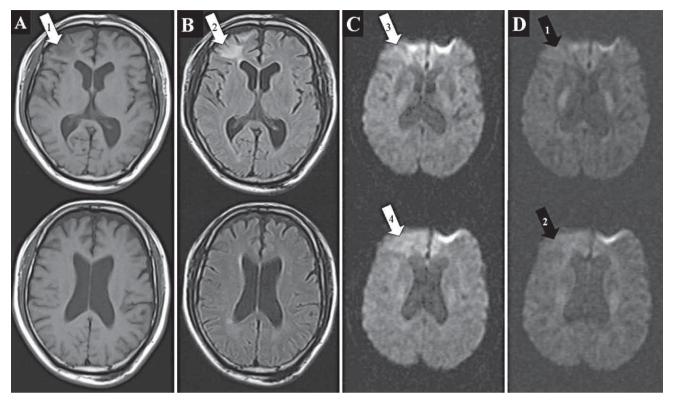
A: T1 MRI (TR/TE/excitation: 500/12/1) shows a patchy of mild hypo-intense signal in the right frontal lobe (hollow arrow 1), and dilatation of lateral ventricles. B: FLAIR MRI (TR/TE/excitation: 6,000/84/1) shows a white matter change of hyper-intense signal in the right frontal lobe (hollow arrow 2). C: Diffusion-weighted imaging (TR/TE/excitation: 8,374/148/1) shows the ischemic change of white matter (hollow arrow 3) is more of upward extension (hollow arrow 4) than T1 and FLAIR MRI. D: Although the follow-up T1, T2 and FLAIR MRI still disclose the same as before, diffusion weighted imaging (8,374/148/1) shows the ischemic change of white matter is reduced (filled arrow 1&2).
